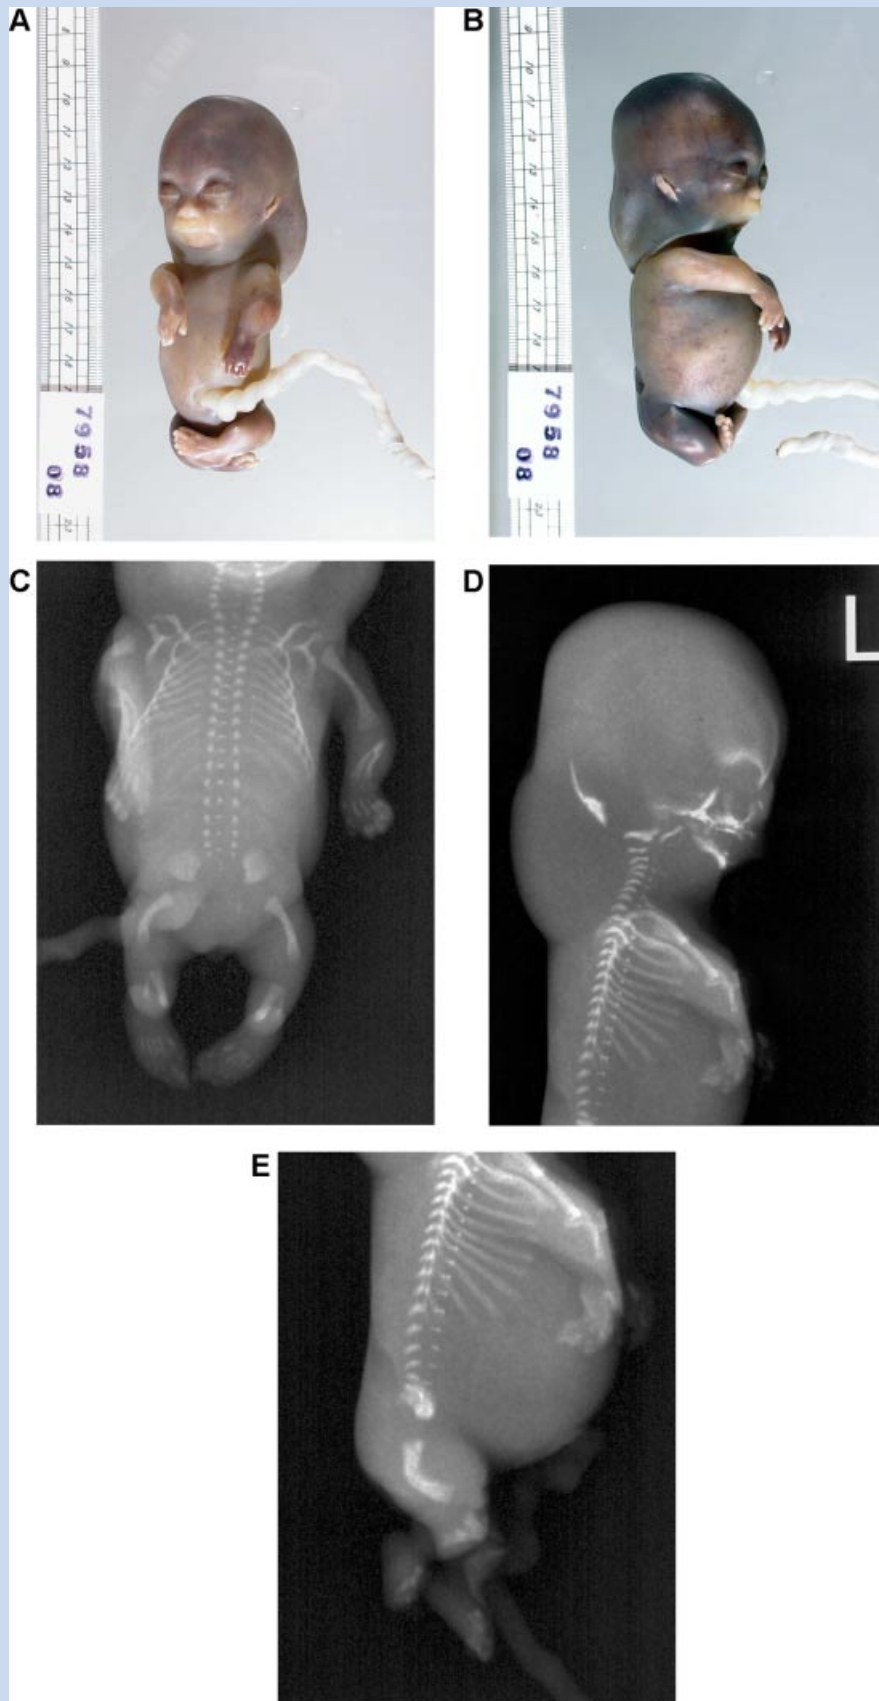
Fetus 1. Mesomelic dysplasia, increased nuchal translucency, tetralogy of Fallot. A,B: Photographs of the 17-week-old fetus show short forearms and legs. C–E: Radiographs show severe hypoplastic/dysplastic forearm and leg bones with bowed femora. There is platyspondyly in the lower thoracic and the lumbar spine. [Color figure can be viewed in the online issue, which is available at www.interscience.wiley.com.]
